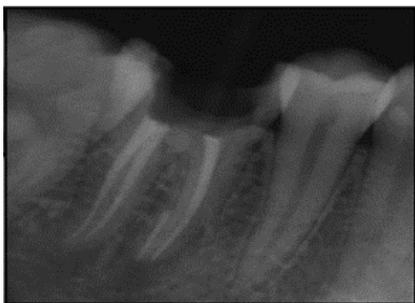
Checking fiber post fit radiographically
